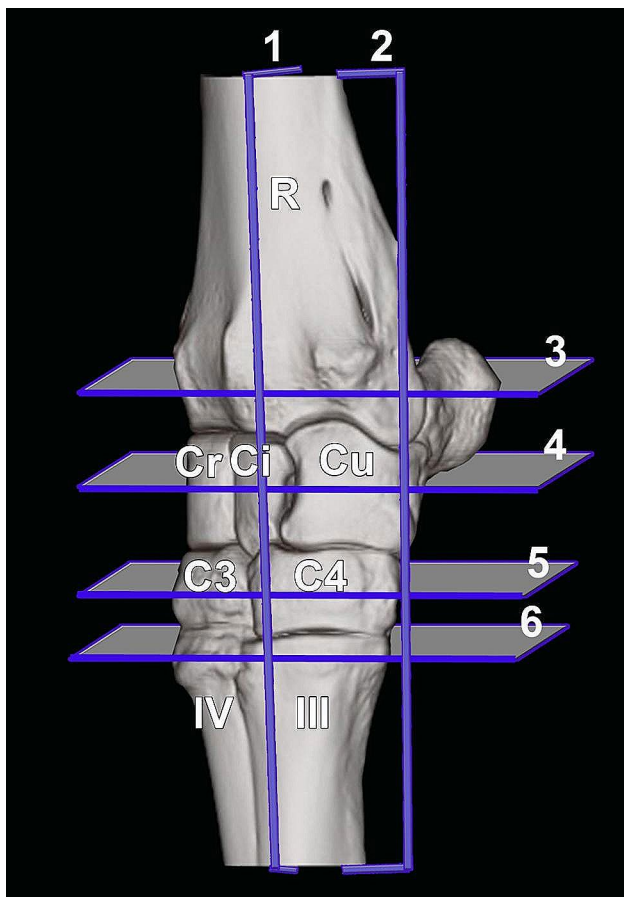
Three-dimensional reconstructed dorsolateral view of the normal dromedary camel carpus. Numbered sections (sagittal, 1; dorsal, 2; and transverse, 3–6) indicate the approximate levels of the selected magnetic resonance images. R, radius; Cu, ulnar carpal bone; Ci, intermediate carpal bone; Cr, radial carpal bone; C3, 3rd carpal bone; C4, fourth carpal bone; III, 3rd metacarpal bone; IV, fourth metacarpal bone
